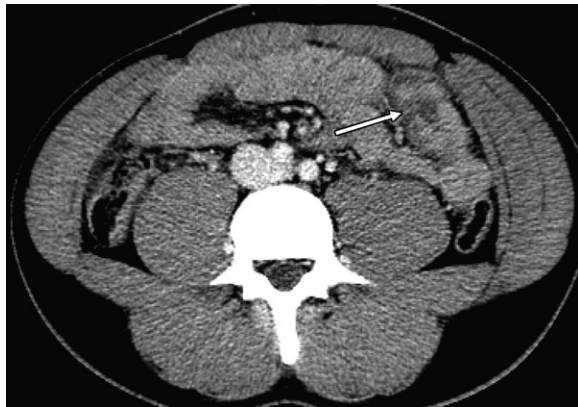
Axial contrast-enhanced CT image in an emergency department patient with trauma. The interpreting radiologist did not see the full-thickness laceration involving the jejunum in the left abdomen (arrow).
